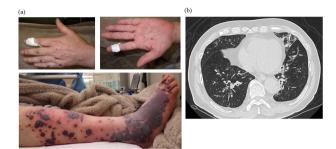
(a) Blood blisters in extremities. After admission, purpura appeared on the right dorsal foot, merged and expanded. Later, purpura spread to the left leg, both fingers and palms, and painful blood blisters developed. (b) CT of the chest on admission shows diffuse airway infiltration in both upper lobes of the lungs, suggesting alveolar haemorrhage.
